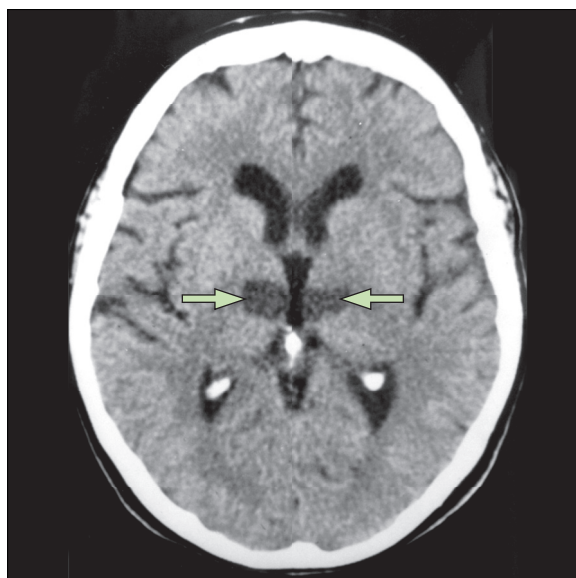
A hypertensive patient who presented with abrupt onset of coma. Delayed CT shows bilateral hypodensities (green arrows) in both paramedian thalami resulting from a stroke involving the artery of Percheron, a variant branch of the posterior cerebral artery that supplies both sides of the medial thalamus (courtesy of Louis R Caplan).
